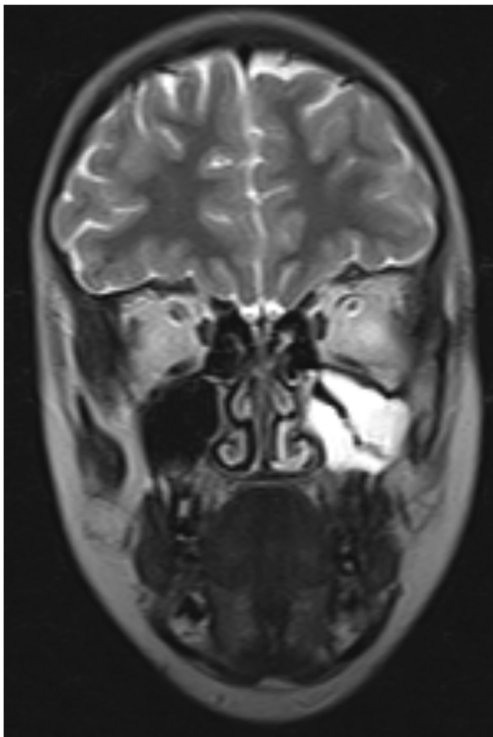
Coronal T2-weighted image shows improvement of target sign
